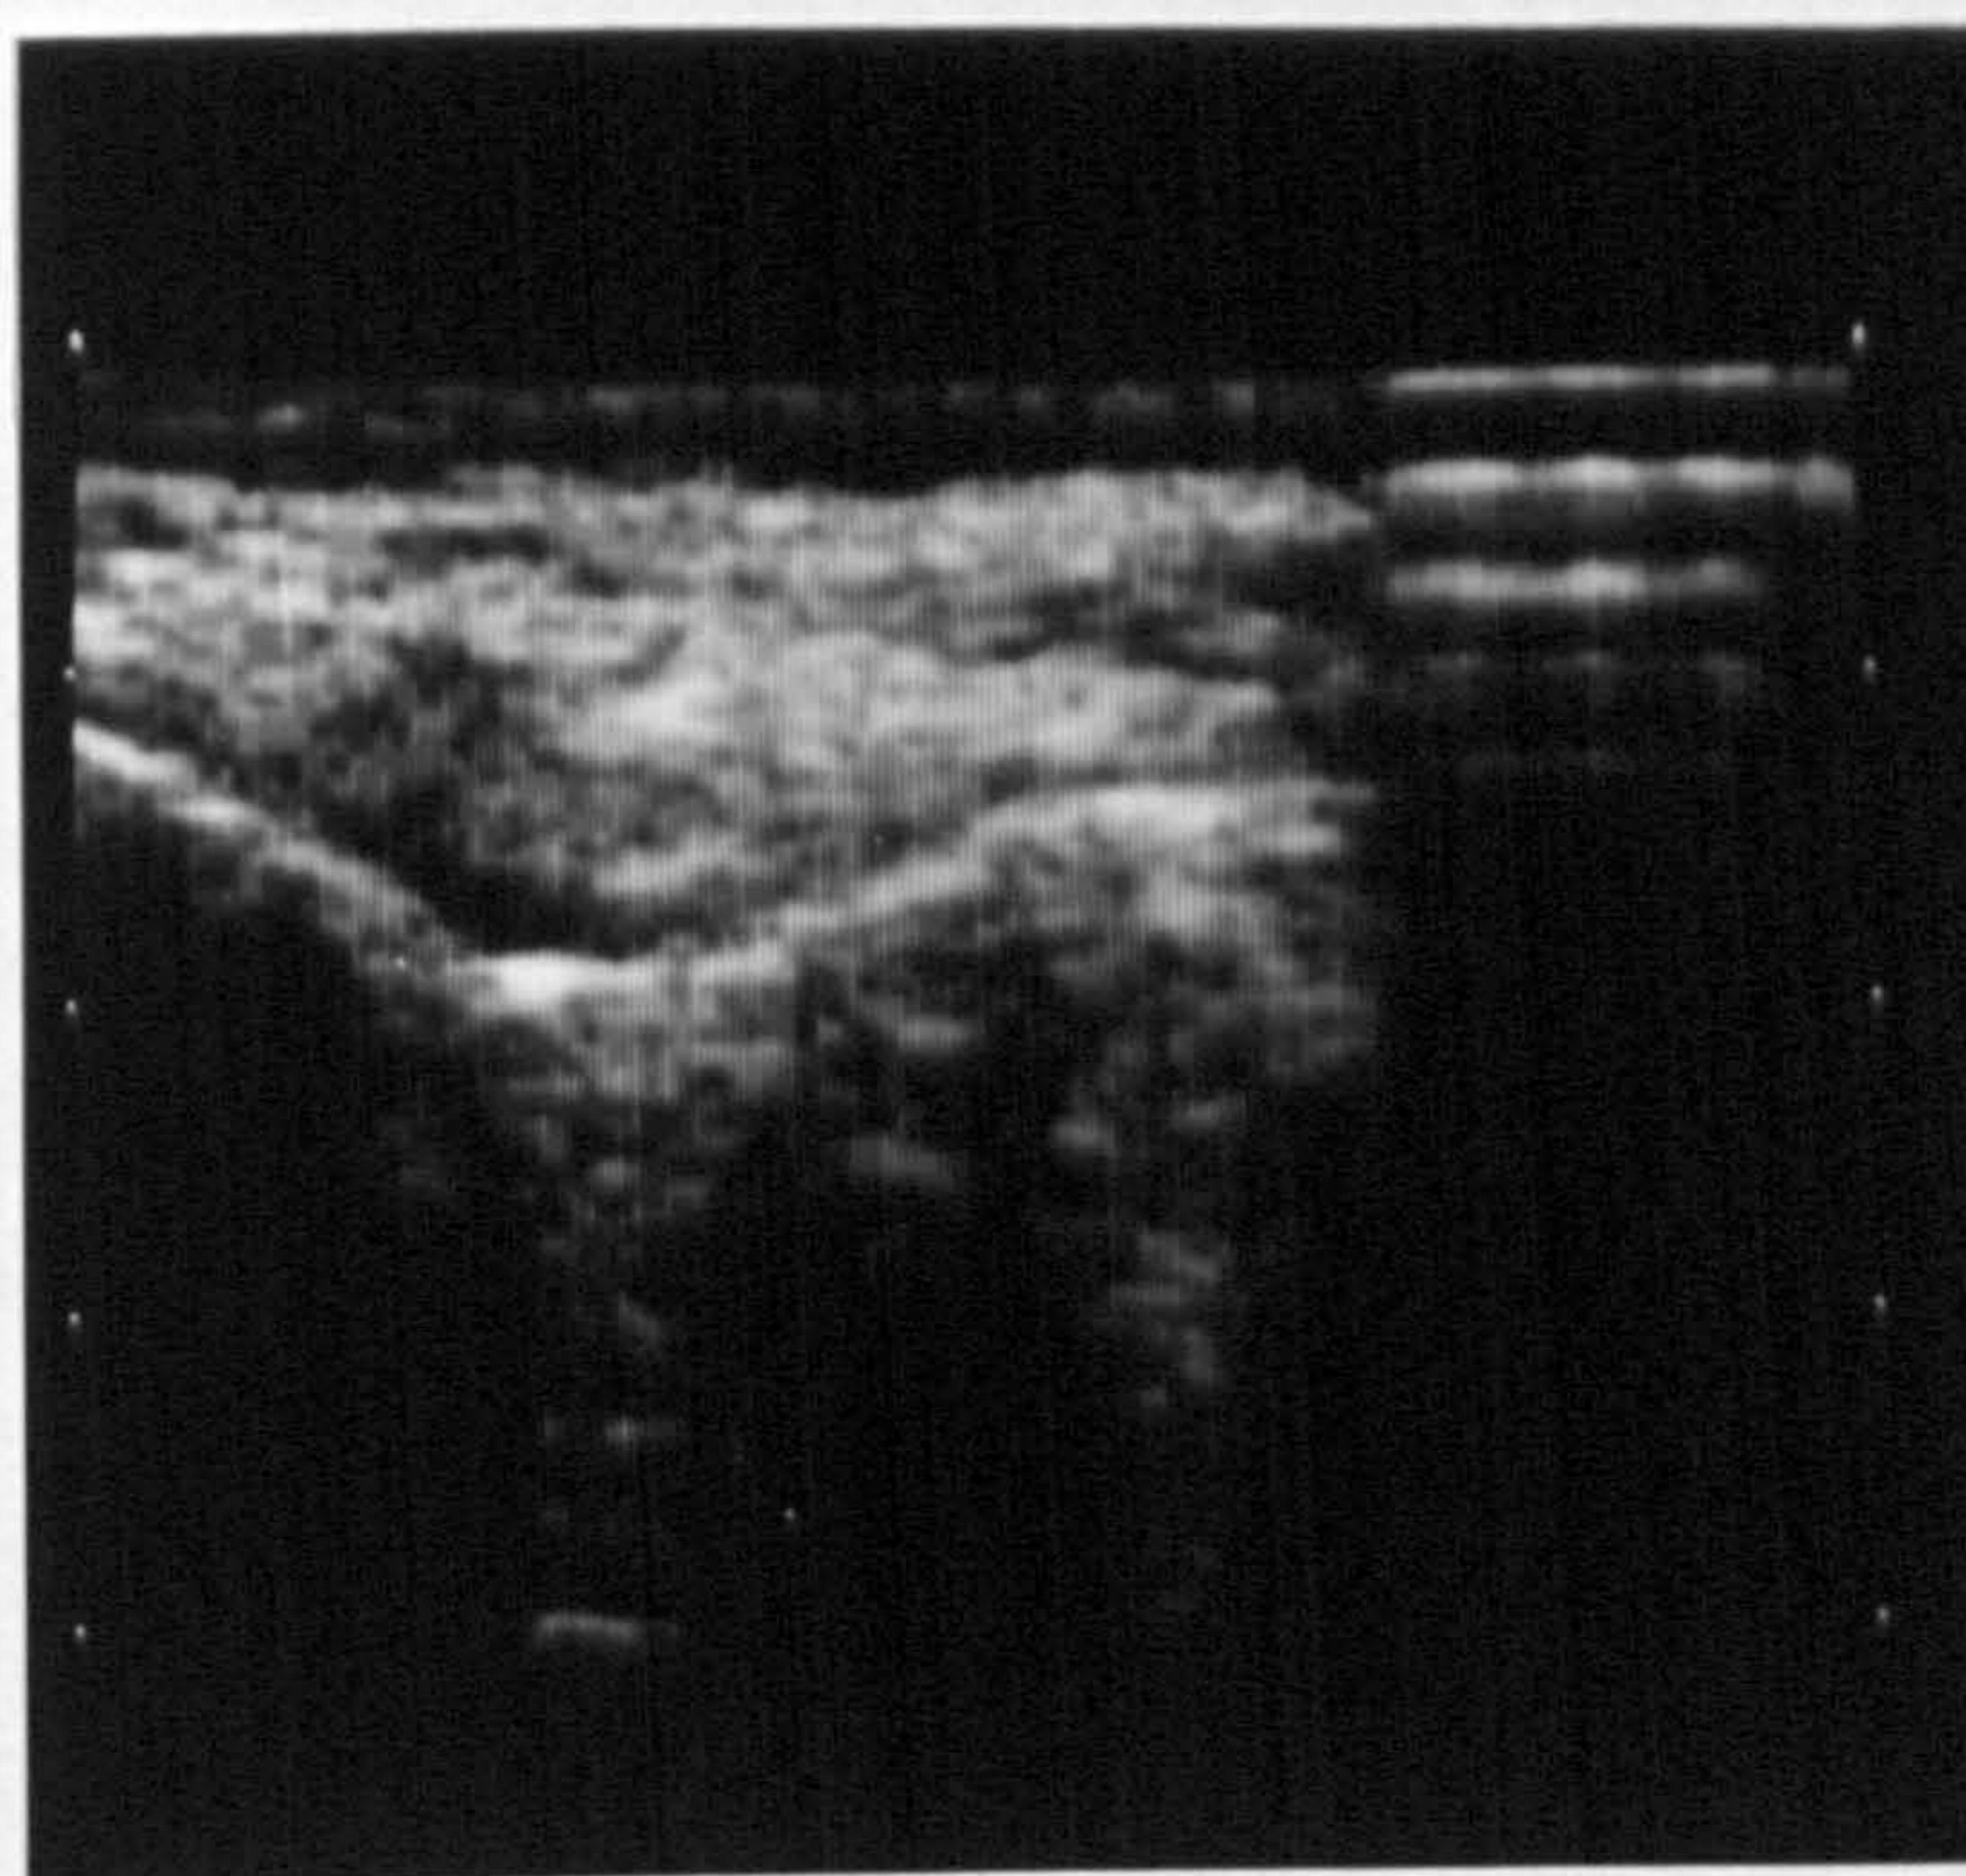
b Ultrasound scan right knee : skyline view
